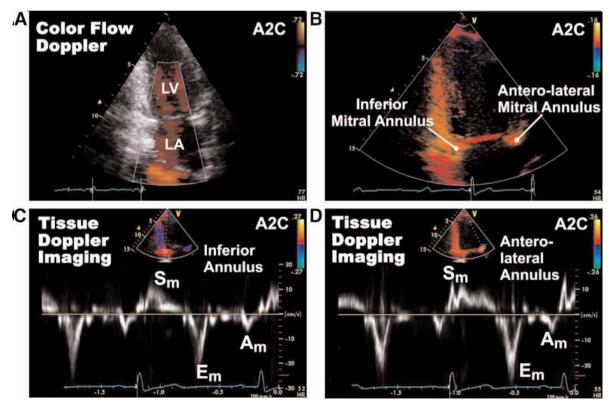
Apical long-axis or apical two-chamber (A2C) view. (A,B, see companion DVD.)
